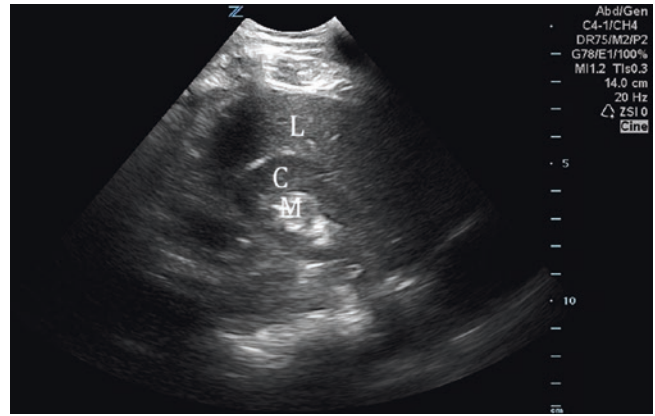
Ultrasound image of the right kidney in the transverse plane. This view similarly demonstrates the cortex (C) and medulla (M) of the kidney. The liver (L) can be seen superior to the kidney. See Video 28.2. (Image courtesy of Stephen Alerhand.)
